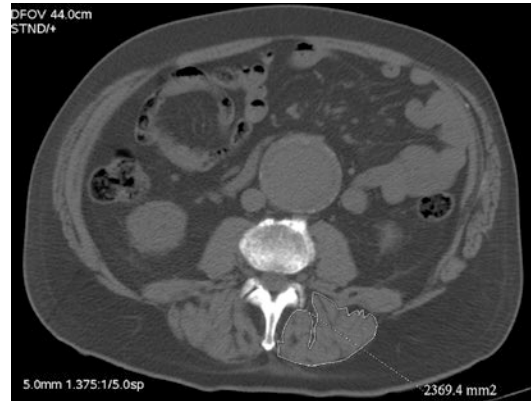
Axial CT section through the mid-abdomen. A region of interest has been drawn around the left paraspinal musculature and its cross-sectional area measured
